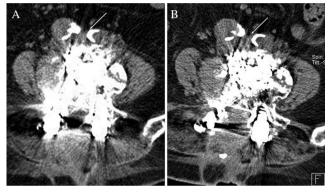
Post-operative CT showing the IVC aneurysm (arrow) was repositioned and maintained (A) post-operative axial CT at 3 months, (B) post-operative axial CT at 7 months.
